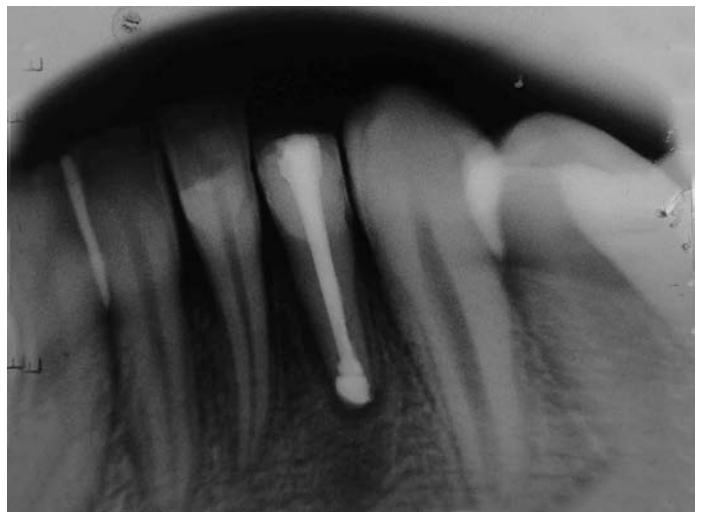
Six months radiographic follow up.
